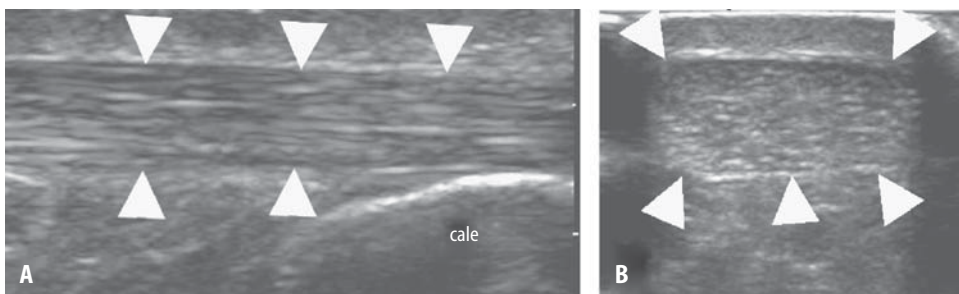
(A) Longitudinal ultrasonographic image of a normal Achilles tendon. Note the echogenic, parallel fibrillar pattern (between arrowheads). (B) Transverse ultrasonographic image of a normal Achilles tendon showing echogenic ovoid shape (arrowheads).
